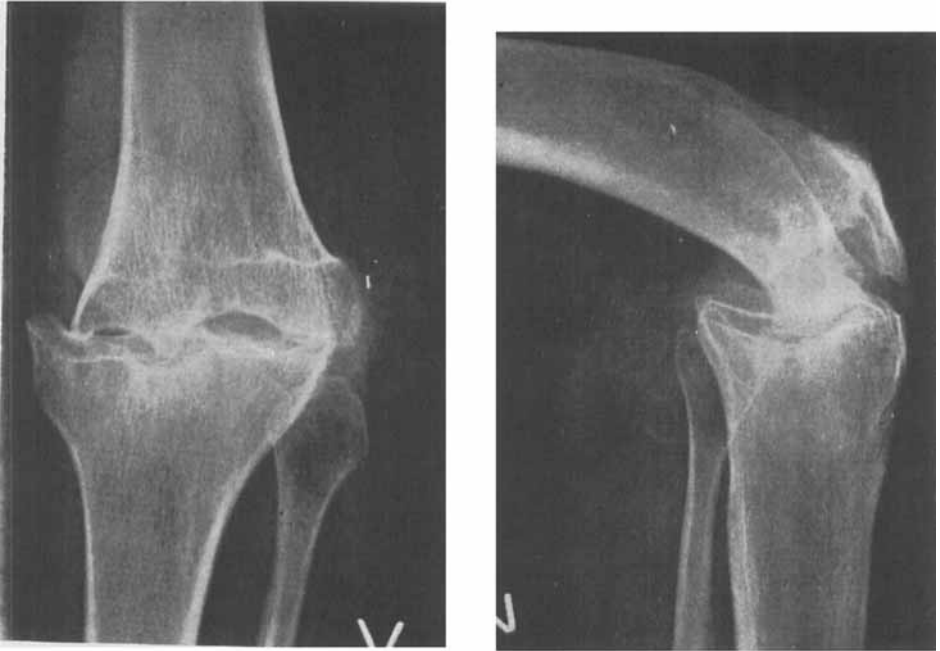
Case 2. Two years after operation. Great resorption of end of femur and consequent gliding thereof to one side. The development has been followed radiographically. There is a great contrast between the radiological findings and the clinical picture, which has steadily improved.
